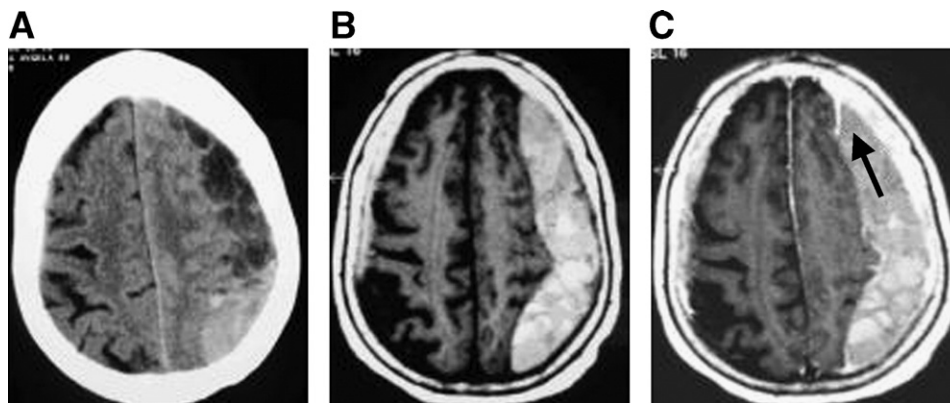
A: Computed tomography showing intra-hematoma septations. B: T₁-weighted MRI showing a hyperintense hematoma. C: Post contrast image evidences the outer, the inner membranes of the hematoma, and the transition zone between the 2 membranes (arrow) as a triangular thickening.
